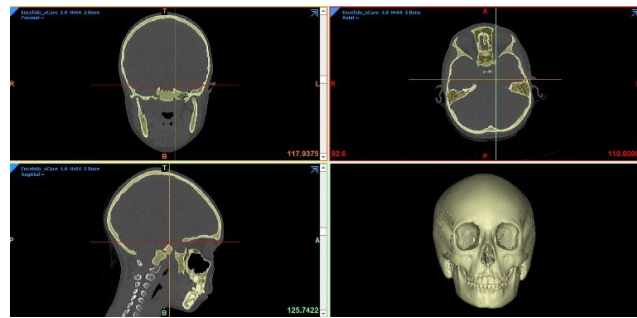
3D reconstruction of the “reference skull model” from axial, coronal and sagittal views from the anonymous patient CT examination.
